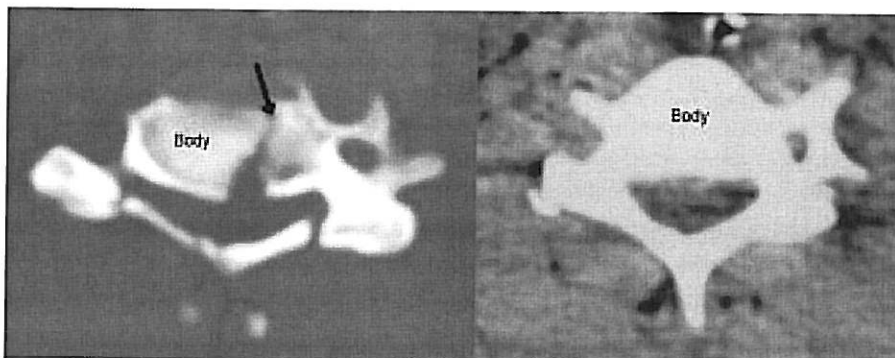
CT showing vertebral fracture (left) and no fracture (right)
